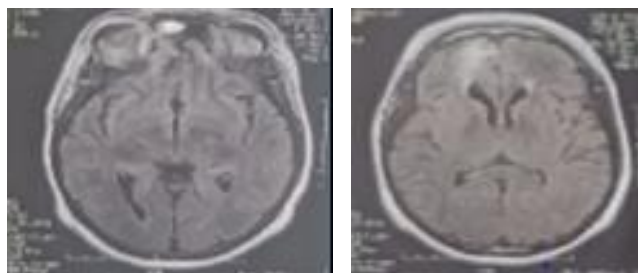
Brain MRI 02 years after the intervention
